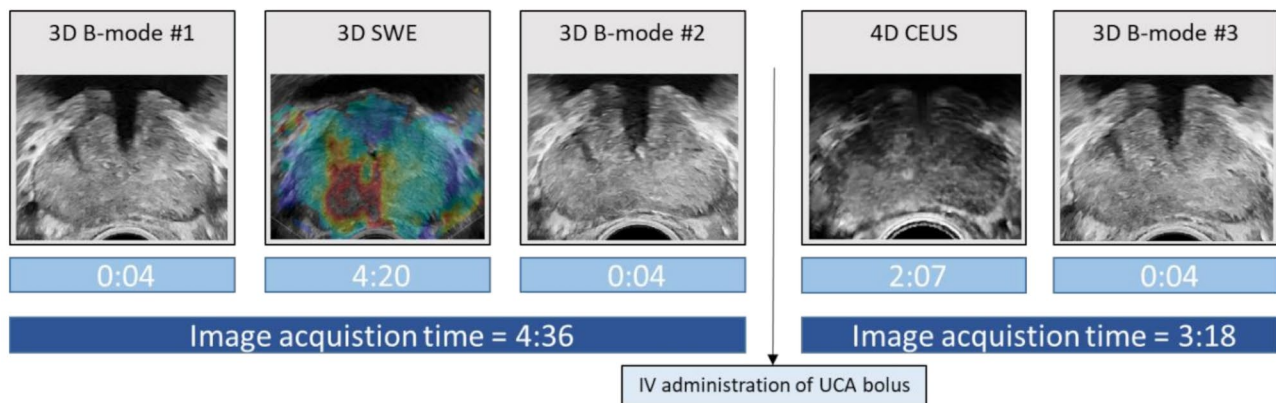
Image acquisition sequence including acquisition time per ultrasound modality. Note that three separate 3D B-mode acquisitions are performed. These can be used for motion detection and compensation. B-mode = Brightness-mode, CEUS = Contrast Enhanced Ultrasound, SWE = Shear Wave Elastography, IV = Intravenous, UCA = Ultrasound Contrast Agent
